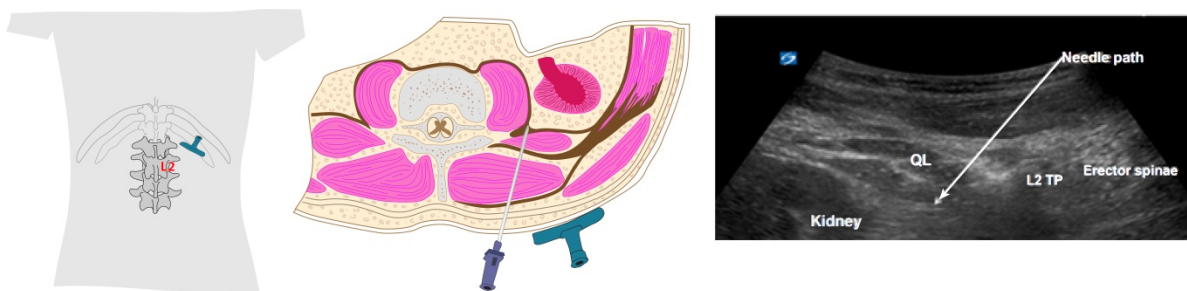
TOP (transverse oblique posteromedial) TQL L2 approach showing transverse oblique Probe placement, in-plane needle placement and ultrasound image
